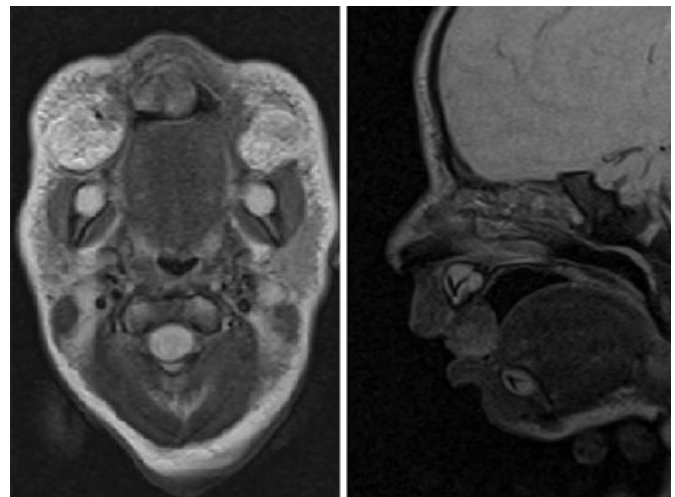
Preoperative MRI, which revealed an exophytic mass (see arrows) emanating from the right maxilla along the anterior inferior margin.
